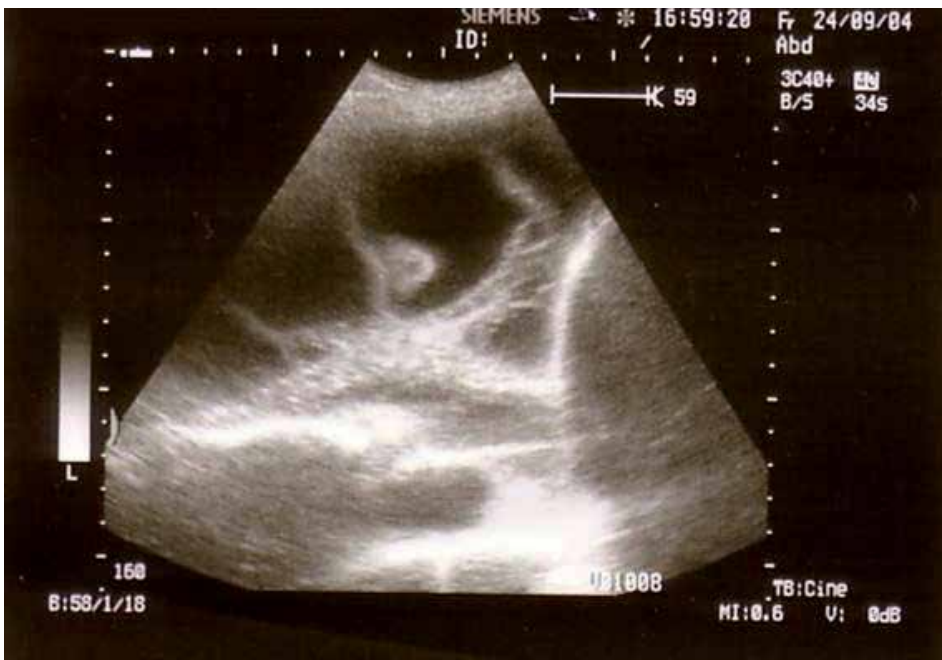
Ultrasound detection of multiple chambers in pleuritis exudativa tuberculosa
